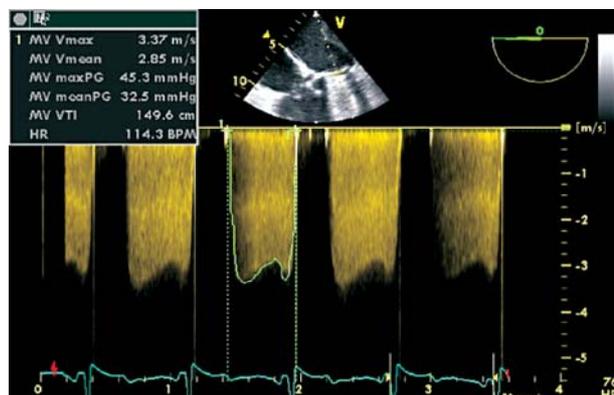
Transoesophageal 4-chamber view and Doppler study of flow through the mitral prosthesis, confirming the findings of the transthoracic study.
